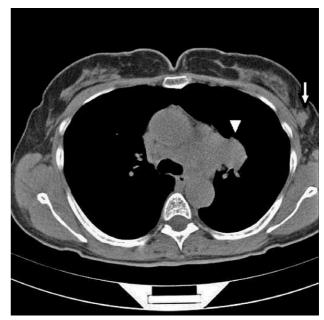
and Fig. 4. The same two breast masses on CT examination.
